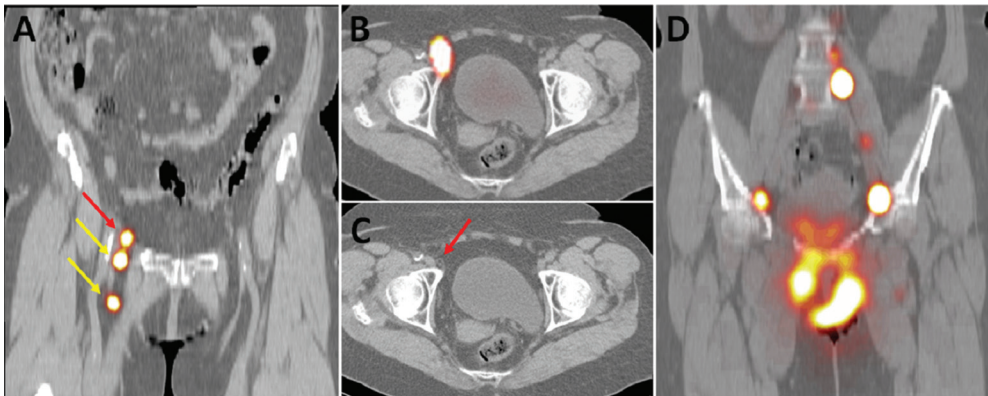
Coronal fused SPECT/CT image shows the sentinel lymph nodes (yellow arrows), one located in the medial superior inguinal zone and one in the medial inferior inguinal zone. The remaining node (red arrow) is a higher-echelon node in the iliac zone (A). Transverse fused SPECT/CT image (B) and CT image (C) also show the higher-echelon node. Coronal fused SPECT/CT image shows higher-echelon nodes along the trajectory of the iliac vessels and the aorta (D).
